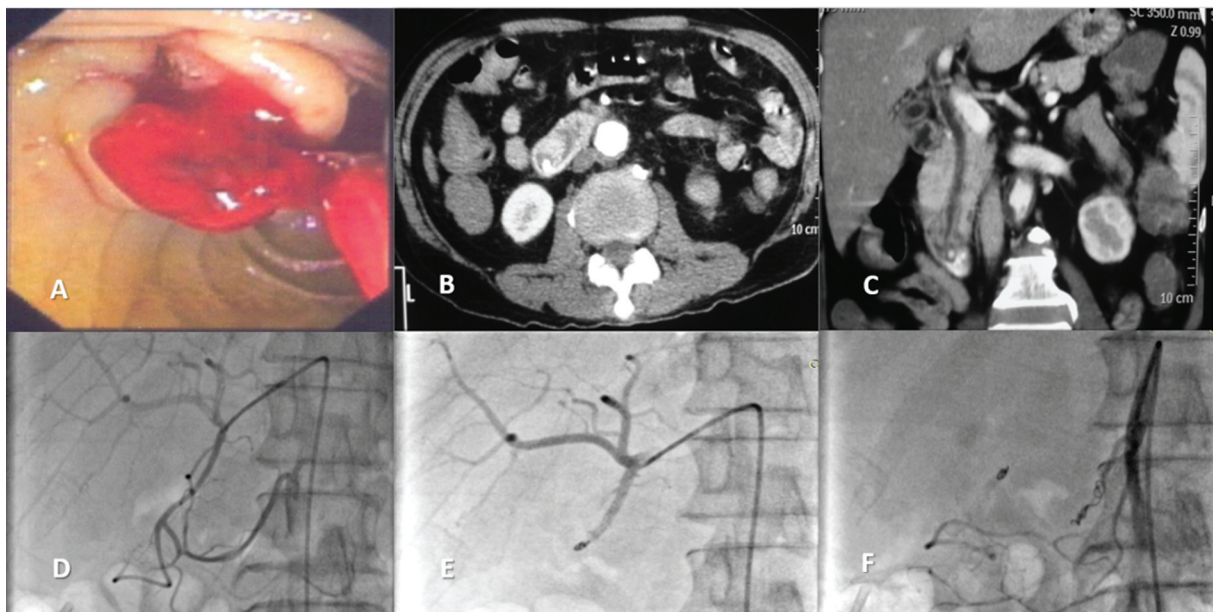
A 45-year-old woman with complain of hematemesis, 2 weeks postsphincterotomy. (A) Upper gastrointestinal (GI) endoscopy shows blood oozing from a focal bulge in the duodenal wall adjacent to the major papilla. (B, C) Contrast-enhanced computed tomography (CECT) of the abdomen shows contrast-filled outpouching adjacent to the major duodenal papilla that is compressing the duodenal wall. (D) Coeliac artery angiogram shows irregularity in the gastroduodenal artery (GDA). (E) Coil embolization of the GDA by the front door technique and (F) inferior pancreaticoduodenal artery by the back door technique.
